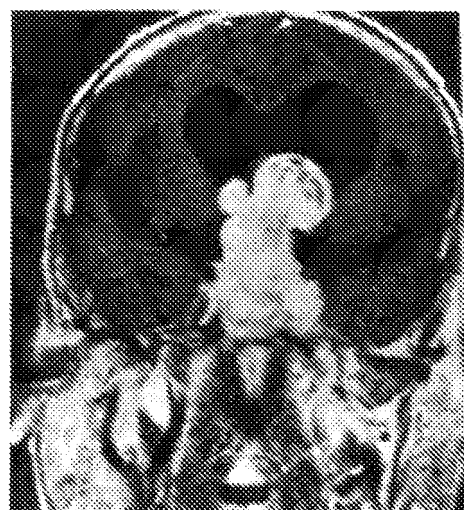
Choice of surgical approach: transsphenoidal versus transcranial? This T1-weighted magnetic resonance image with gadolinium enhancement demonstrates a large macroadenoma that shows mostly vertical growth with no significant middle fossa extension. For this reason, a primary transsphenoidal approach was chosen with adequate decompression of the visual apparatus.
